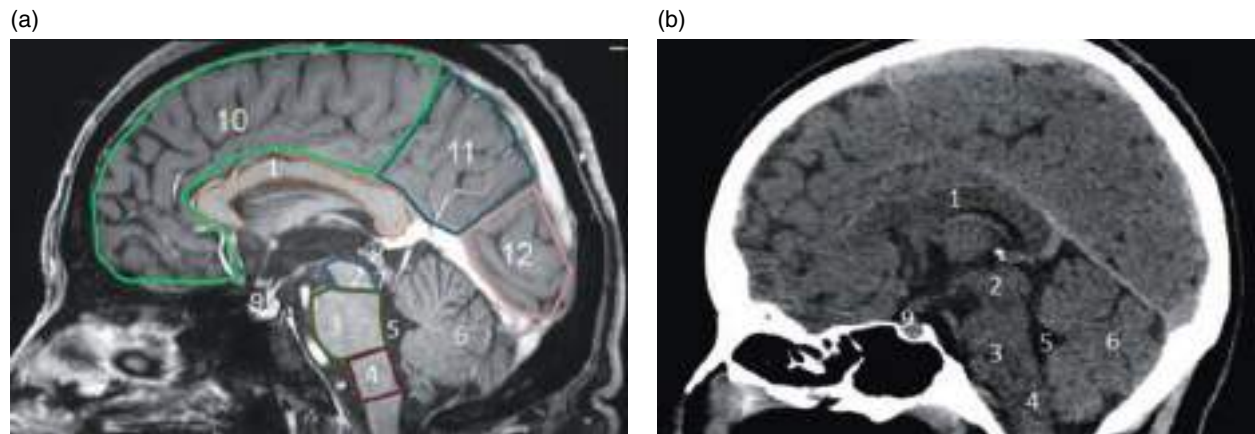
Sagittal anatomy of the brain in the midline. (a) Sagittal contrast-enhanced T1-3D weighted magnetic resonance image (MRI). (b) Sagittal noncontrast MPR CT image of the skull. 1, corpus callosum; 2, midbrain; 3, pons; 4, medulla oblongata; 5, fourth ventricle; 6, cerebellar vermis; 7, cerebral aqueduct; 8, quadrigeminal plate; 9, sella turcica; 10, frontal lobe; 11, parietal lobe; 12, occipital lobe.
